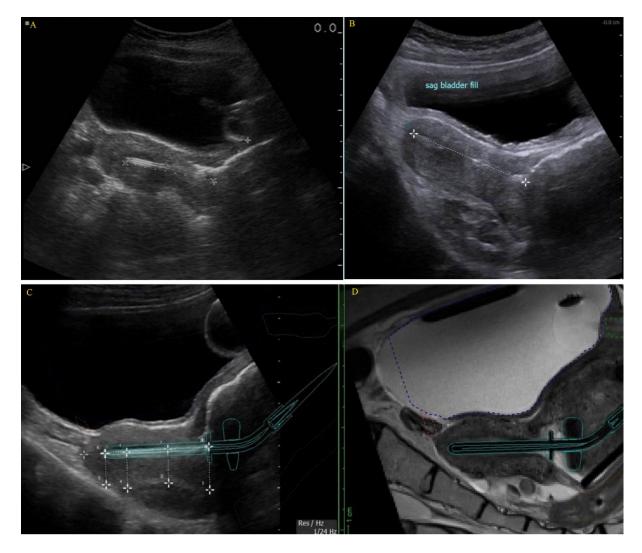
Example of improvements in quality of ultrasound images
